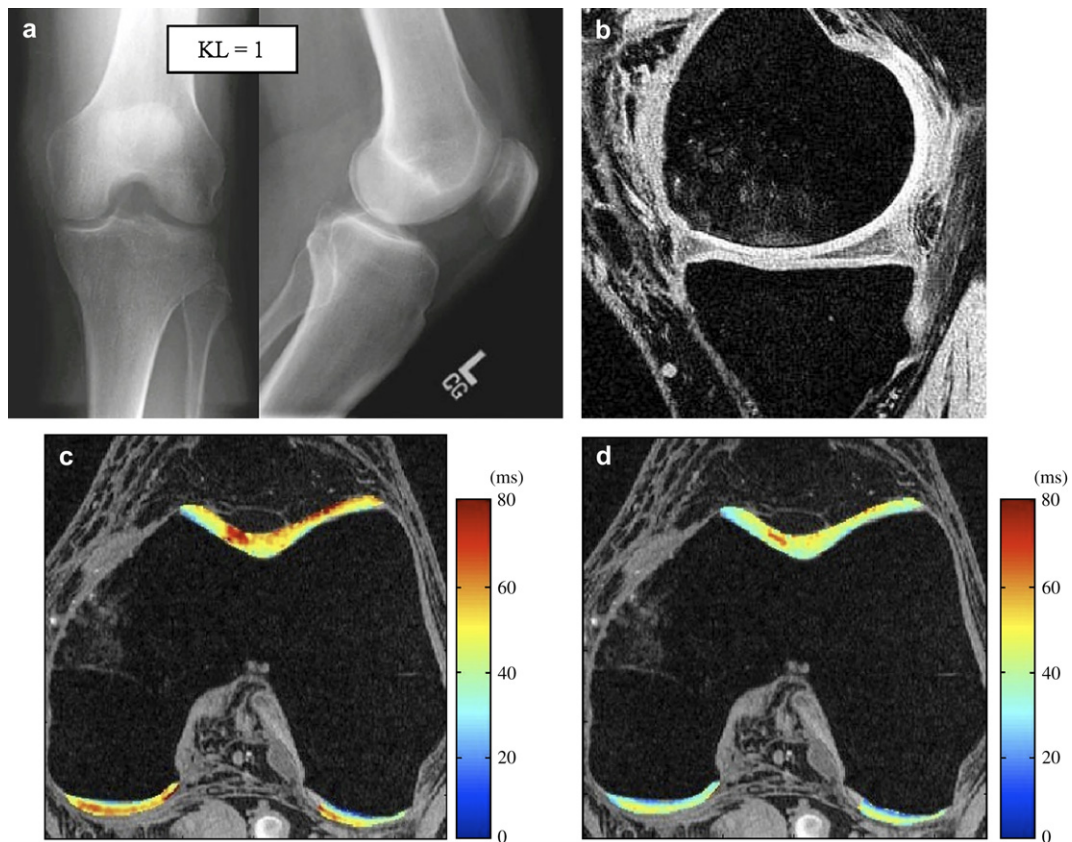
Radiographs (a), T_1 -weighted water excitation SPGR image (b), $T_{1\rho}$ map (c) and T_2 map (d) for a patient with mild OA (male, 66). From radiographs, no significant joint space narrowing was seen, but minimal osteophytes were observed in femoro-tibial joint and minimal to mild osteophytes were observed in femoro-patellar joint, resulting in a KL score of 1. From MR images, minimal osteophytes were also seen in femoro-tibial and femoro-patellar joints. The cartilage in medial femur and femoro-patellar compartment had grade 1 thinning. The average $T_{1\rho}$ value was 45.5 ± 14.5 ms and the average T_2 value was 35.0 ± 10.9 ms in cartilage.
